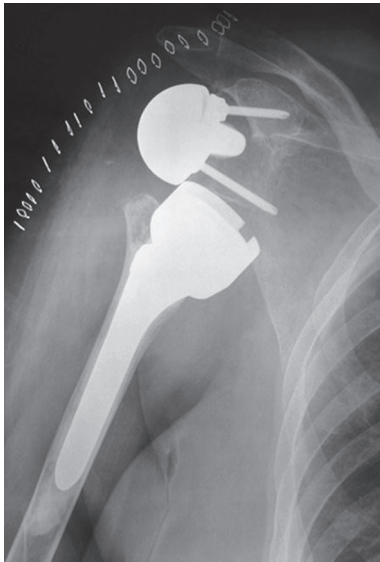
Radiograph demonstrating dislocation of the reverse endoprosthesis of the shoulder
